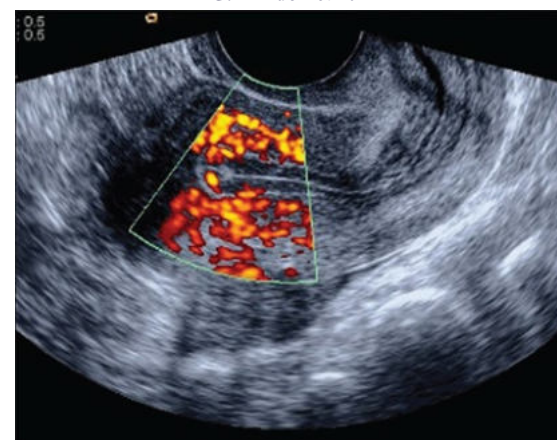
Endometrial thickness in color doppler
